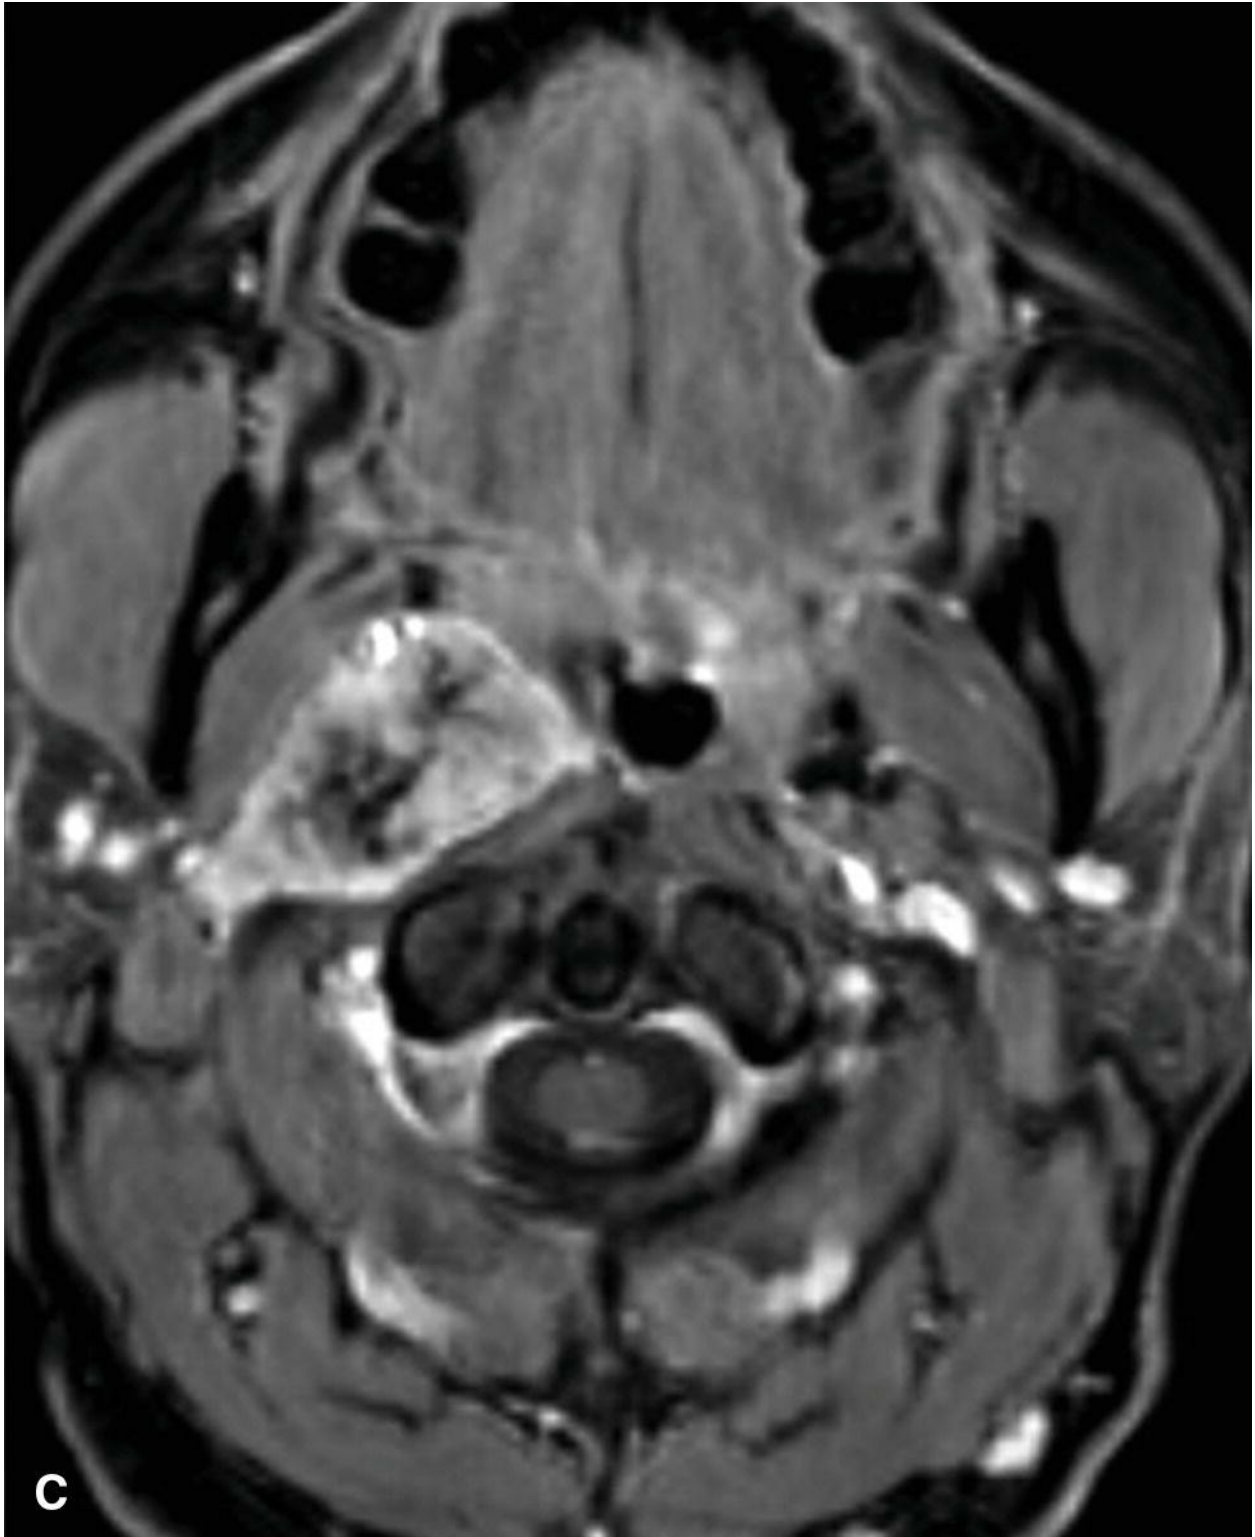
“Salt-and-pepper” appearance of paraganglioma. Fifty-nine-year-old man presenting with fullness in the left neck. T1-weighted image
